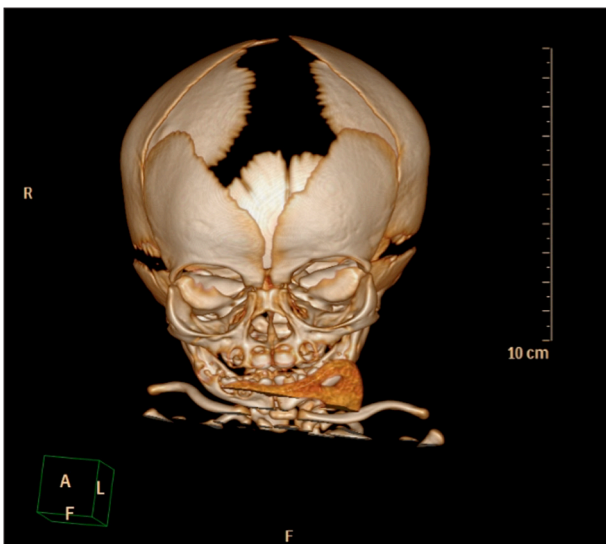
Upper view of 3D cranio-encephalic CT scan demonstrating a large sagittal suture and anterior fontanelle.
